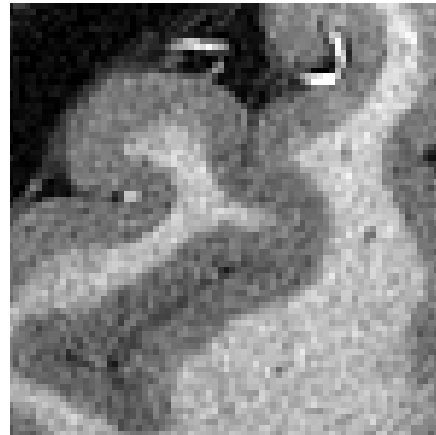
Images courtesy of Dr. Jeff H. Duyn, Advanced MRI Section, Laboratory of Functional and Molecular Imaging, National Institute of Neurological Disorders and Stroke.
